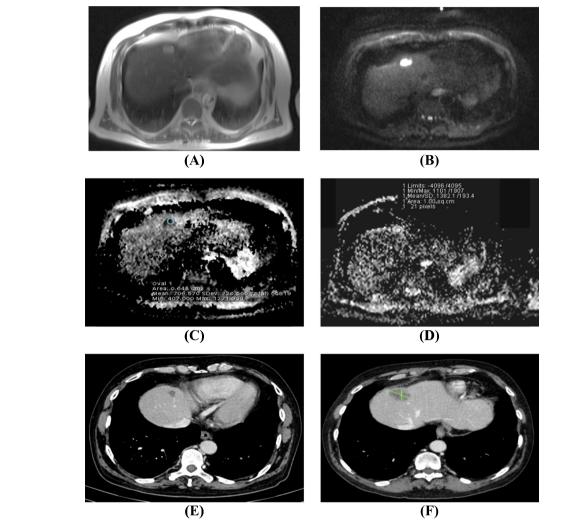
Case (3): A 69 year old male patient with history of rectal adeno-carcinoma with solitary hepatic metastasis a) Baseline T2 axial MRI revealed a small solitary hepatic dome hyper intense lesion at segment IV A b) corresponding axial baseline diffusion weighted image of the previous T2 target lesion with b value of (800 m2/sec) shows the lesion displaying hyper intense signal. c) pre therapeutic ADC image revealed diffusion restriction and ADC value of 0.71 x10-3 m2/sec. (d) post therapeutic (21 days after chemotherapy) ADC map showing marked increase in the ADC value measuring 1.38 x10-3 m2/sec (e) base line pre chemotherapy CT portal phase; shows the same small hypo dense target lesion measuring about 1.4 cm. (f) 2 month follow up CT portal phase revealed significant increase in the size of the lesion which was seen measuring about 3.2 cm (progressive disease according to RECIST criteria)
